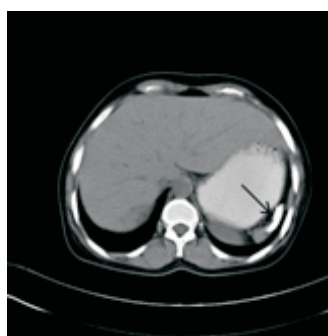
Axial plain CT scan image showing a calcified mass in the splenic fossa.
